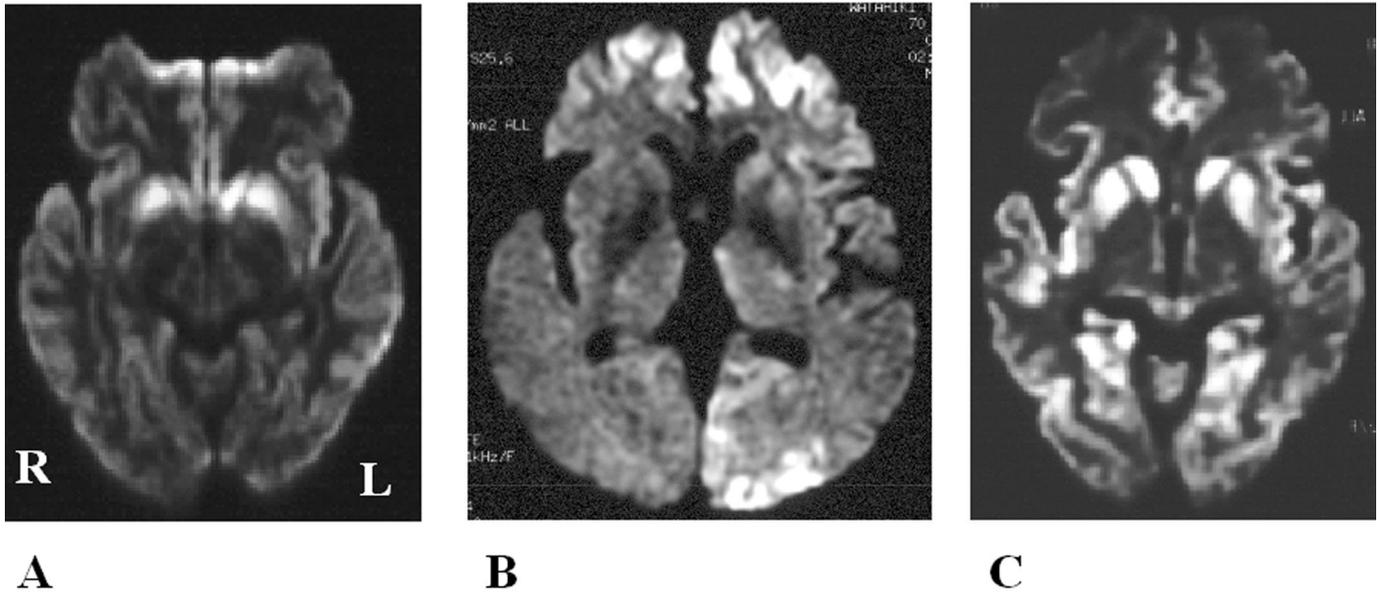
MRI changes seen in Creutzfeldt–Jakob disease. Three patterns of high-intensity lesions were seen: striatal lesion (A), cerebral cortical lesion (B), and a combination of both lesions (C).
